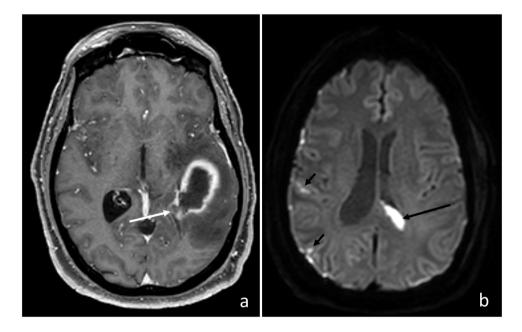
Axial MRI of the brain. T1-weighted post-contrast image (a) shows discontinuity in the peripheral enhancement of the abscess where the abscess has ruptured into the left lateral ventricle. Diffusion weighted image (b) shows marked restricted diffusion dependent within the left lateral ventricle (long black arrow) compatible with ventriculitis as well as small foci of restricted diffusion in the sulci (short black arrows) compatible with meningitis.
